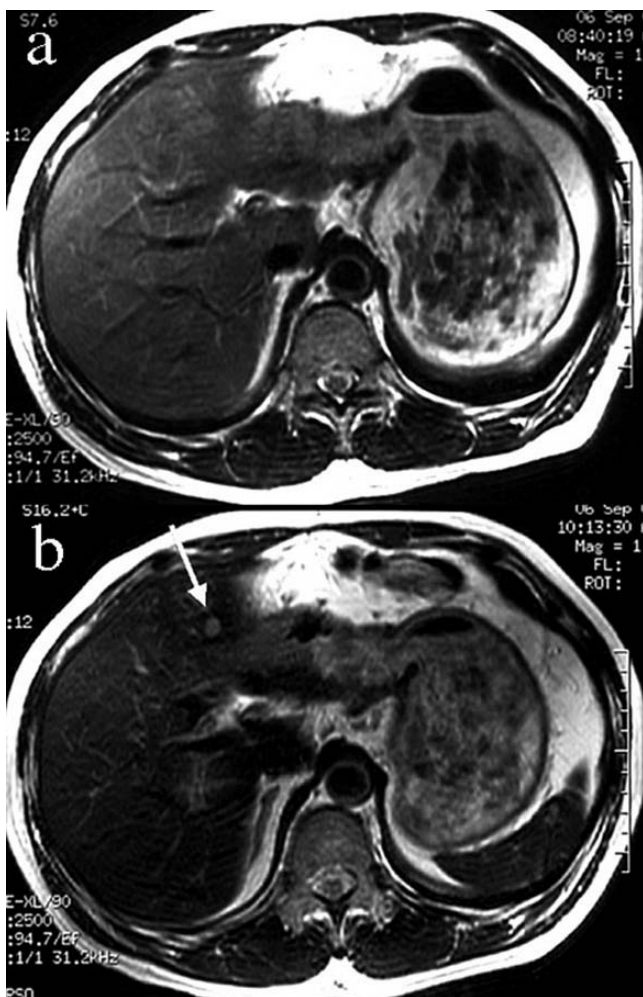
Liver metastasis from gastric cancer in a 52-year-old male: Unenhanced vs SPIO-enhanced MR imaging. No lesion is found on unenhanced T_2 -weighted FSE (a). SPIO-enhanced MR imaging reveals a small mass exhibiting decreased phagocytic activity in the lateral segment (b; arrow).
